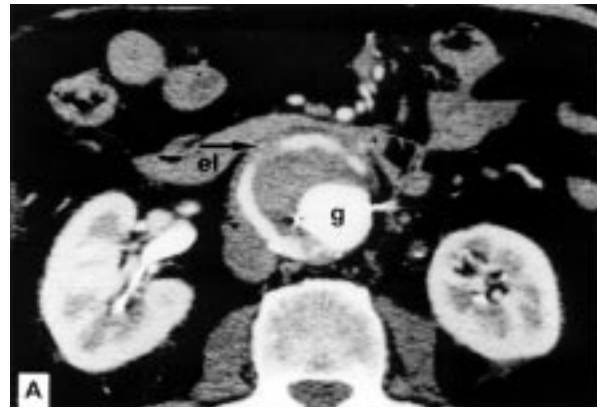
Patient with endoleak after placement of EVT tube graft. A, Transverse CT scan image shows that endoleak (*el*) takes on C-shaped configuration within aneurysm sac. Endovascular graft (*g*) is also shown. B, Three-dimensional reconstruction shows zig-zag configuration of proximal stent (*s*) and endoleak (*el*) originating adjacent to stent. Endoleak travels around aneurysm sac and has outflow through a patent lumbar vessel.
